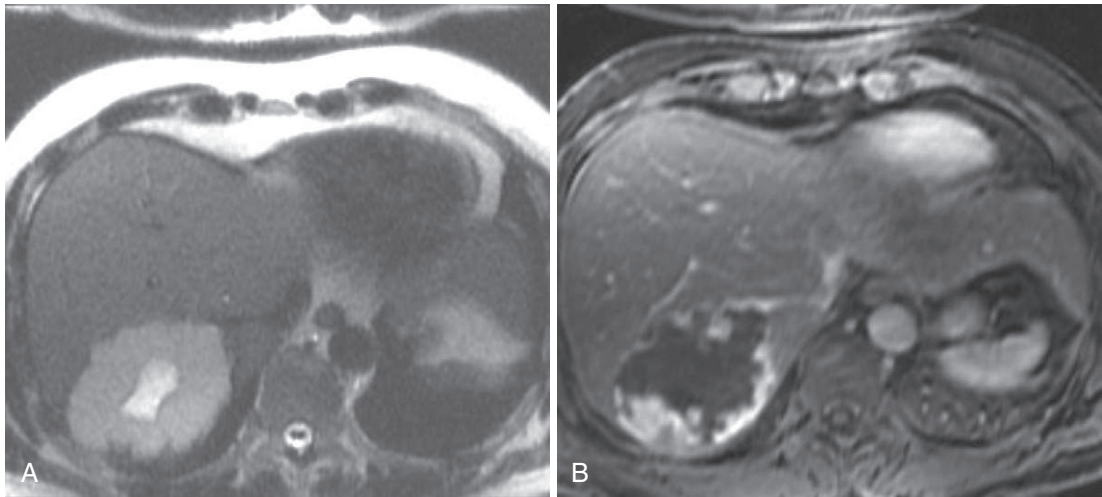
Giant hemangioma with cystic degeneration. A, The axial heavily T2-weighted image reveals a large hemangioma in the posterior segment with central hyperintensity. Whereas the periphery of the hemangioma exhibits the typical early nodular peripheral enhancement (B) with complete fill-in on the delayed image (C), the central cystic focus fails to enhance.
